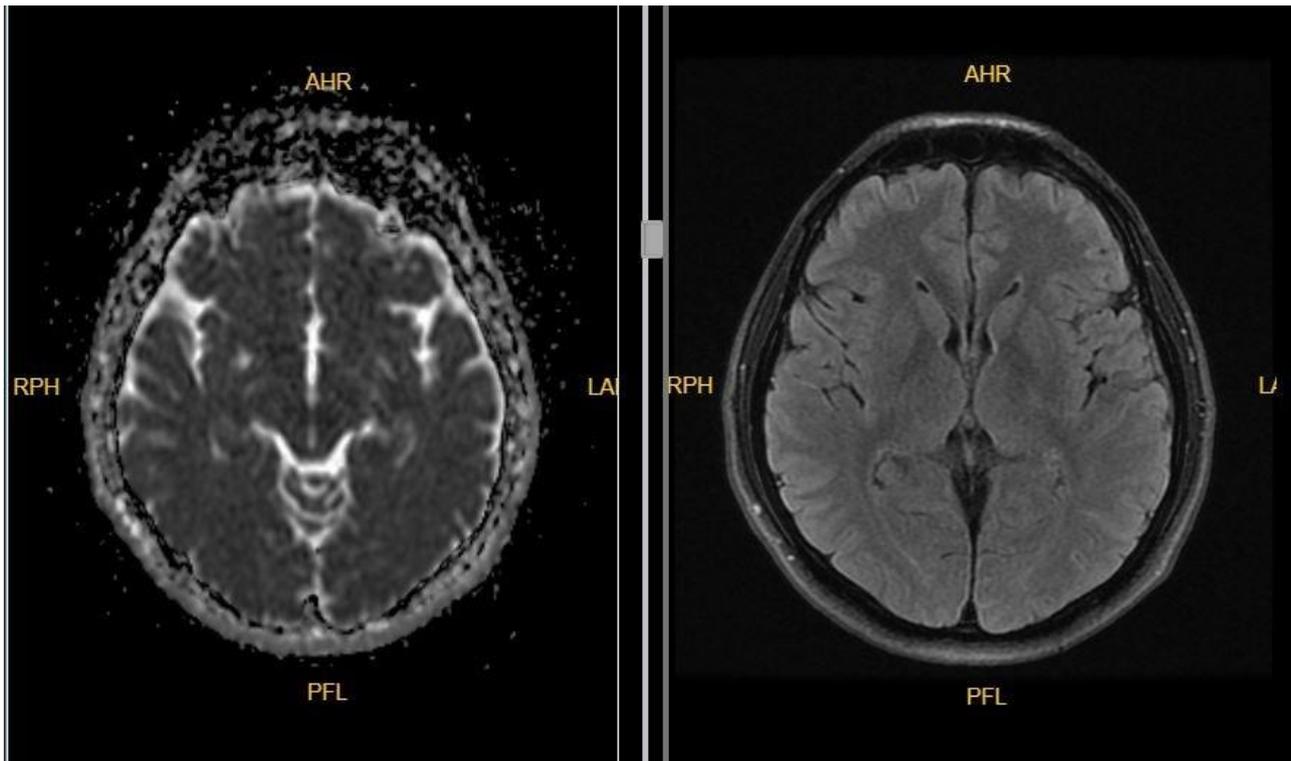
Cranial diffusion MRI: No acute ischemia and gross intracranial pathology/hemorrhage. MRI: magnetic resonance imaging
